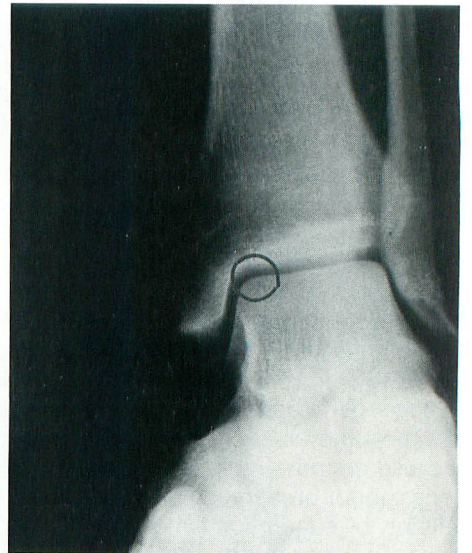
Corresponding AP radiograph, defect not recognizable.
